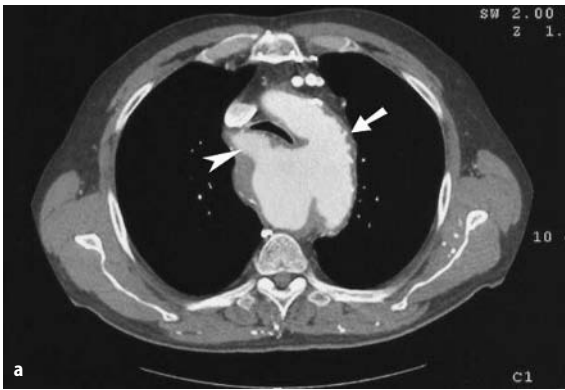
a Axial CT at the level of the aortic arch (*arrow*); patient with aneurysm of an aberrant right subclavian artery (*asterisk*). b 3D reconstruction; posterior view demonstrating the extent of an aneurysm to advantage (*arrowhead*); origin of the right subclavian artery on the posterior aspect of the aortic arch (*arrow*). (Courtesy of Reinhard S. Pamler, Ulm, Germany)
